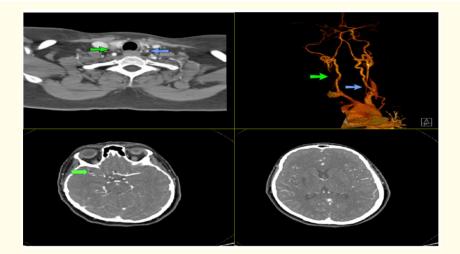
Cerebral CT Angiogram
